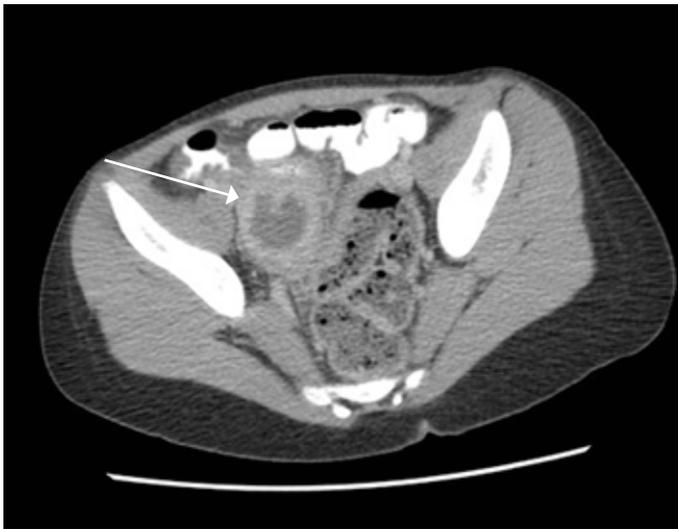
CT scan showing perforated appendix with collection (arrow).
